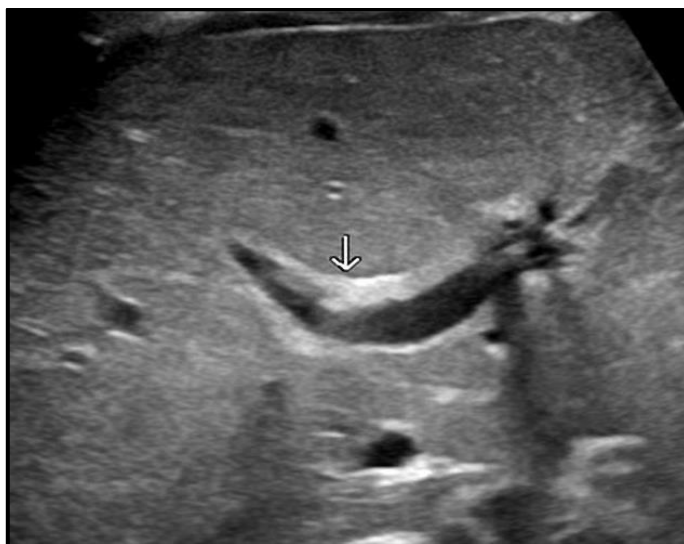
Ultrasound transverse scan at the porta, the common bile duct is not visualized. The portal vein and hepatic artery are identified. There is increased echogenicity along anterior wall of portal vein consistent with triangular cord sign⁽¹¹⁾.
